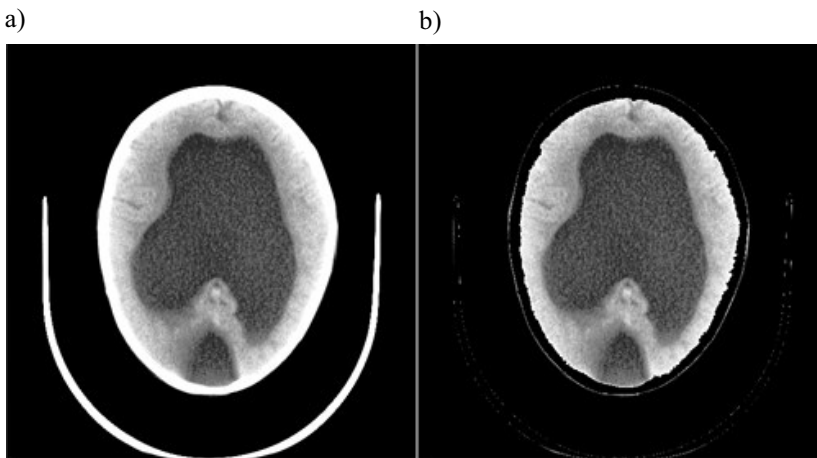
Result of skull and CT tube removal: a) input image; b) image after preprocessing
